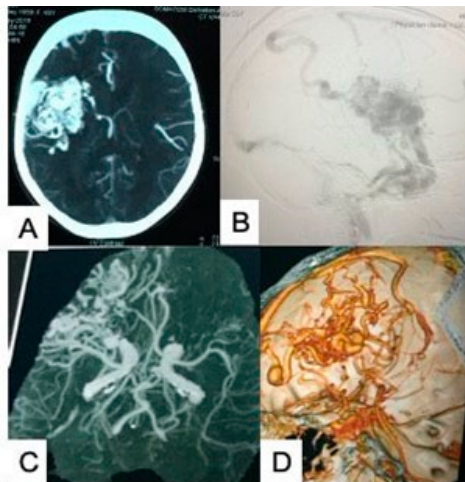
(A,B) CT angiogram showing a compact AVM of the lateral frontoparietal region fed by an MCA and venous drainage toward the superior sagittal sinus. (C,D) CT angiogram showing the right frontal diffuse AVM fed by branches from the middle cerebral artery and venous drainage toward the superior sagittal sinus. Source: Figure by authors.
